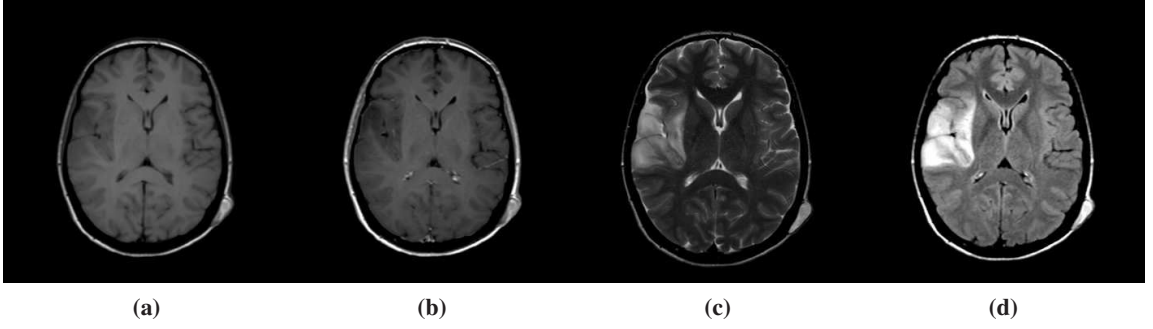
Images sequences for the visualization of a Low grade glioma. (a) T1, (b) T1 contrast enhanced (no enhancement of the tumor), (c) T2, (d) FLAIR images.
